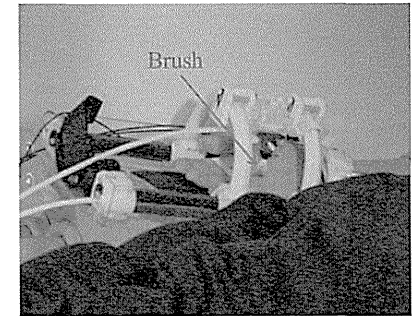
Subject's hand equipped with the developed stimulator. The brush stimulation is provided to the palm in the MRI.
